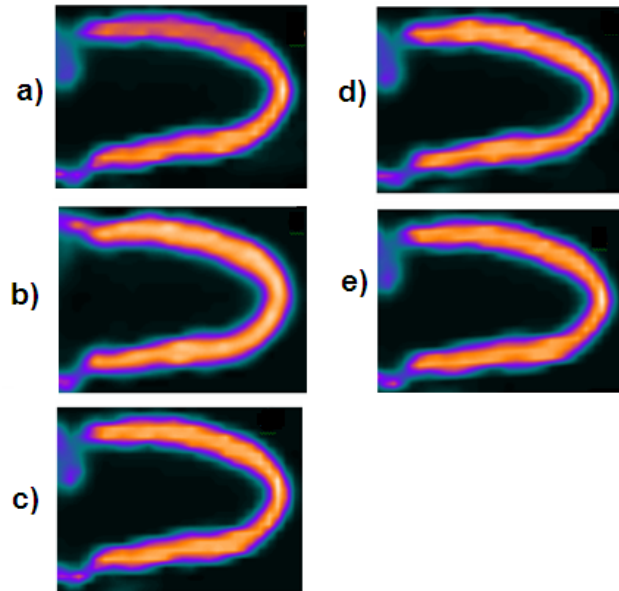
As for Figure 3.6, but for SPECT datasets.
